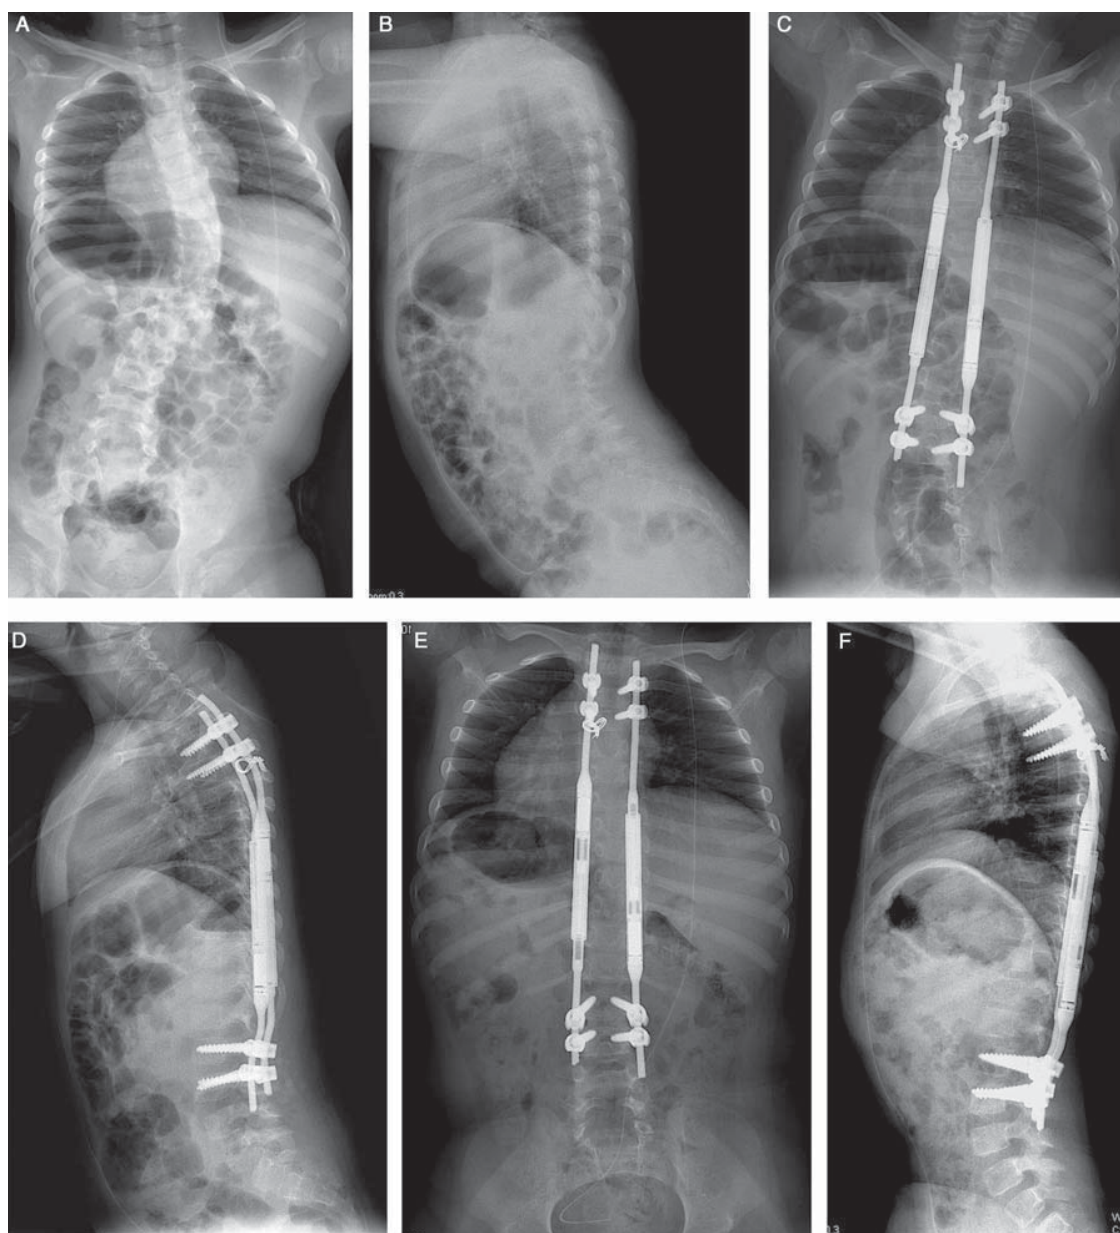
(A–F) Posteroanterior and lateral radiographs of a 5.5-year-old girl with neuromuscular scoliosis and right thoracic curve of 45° before (A, B) and after (C, D) dual MCGR. The patient has had monthly MCGR lengthening during the course of 7 months and achieved 12 mm and 31 mm of T1–T12 and T1–S1 height, respectively (E, F). MCGR indicates magnetically controlled growing rod.
